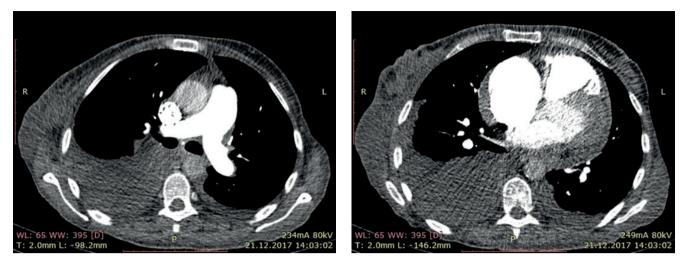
CT of 50-years-old female patient: axillary lymphadenopathy. Hydropericardium. Bilateral hydrothorax.
